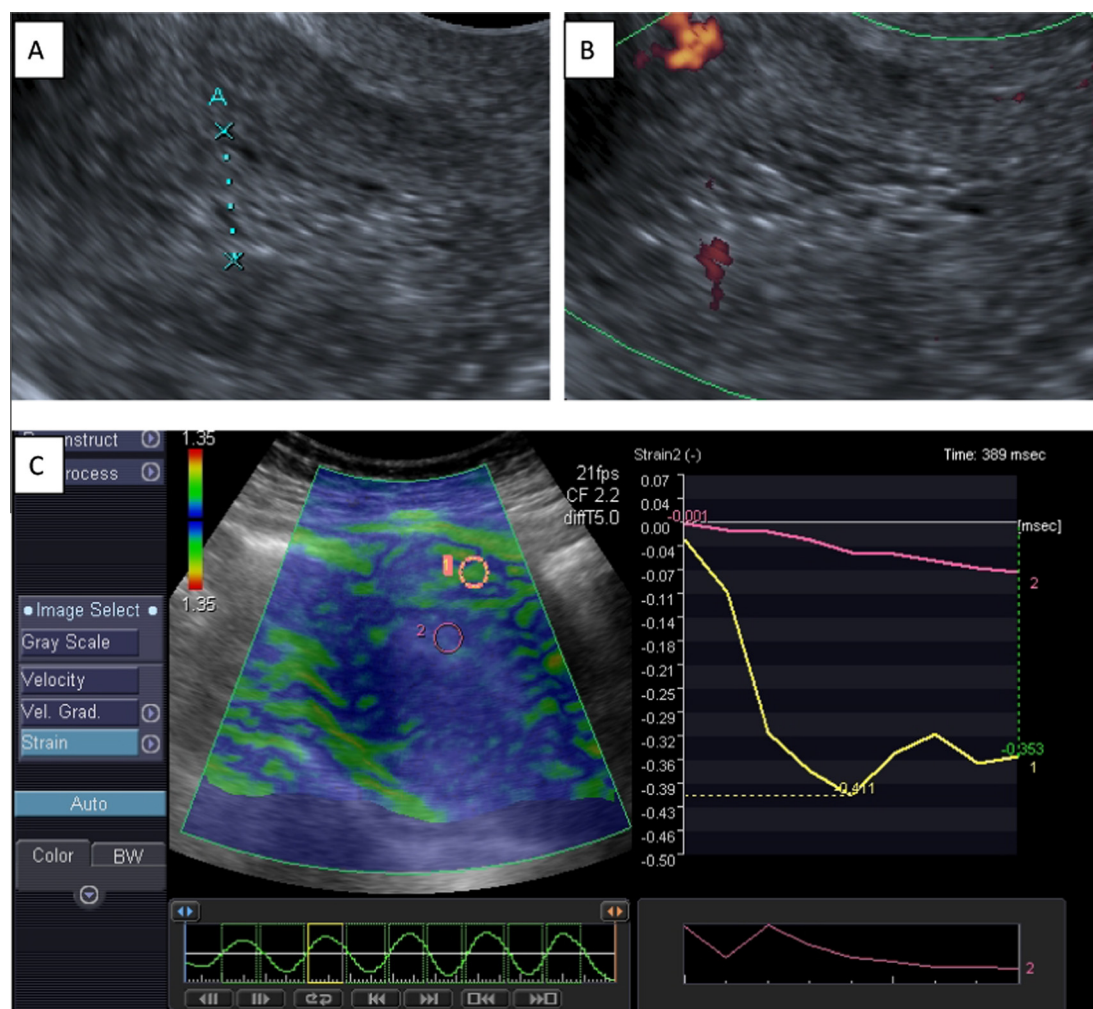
Ultrasound images of a female patient, aged 55 years with thickened endometrium (confirmed to be typical endometrial hyperplasia by pathological examination). B-mode ultrasound image (A), Power Doppler image (B) and TV elastogram (C) show endometrial thickness = 15 mm with no significant increase vascularity, light blue color and SR = 2.
